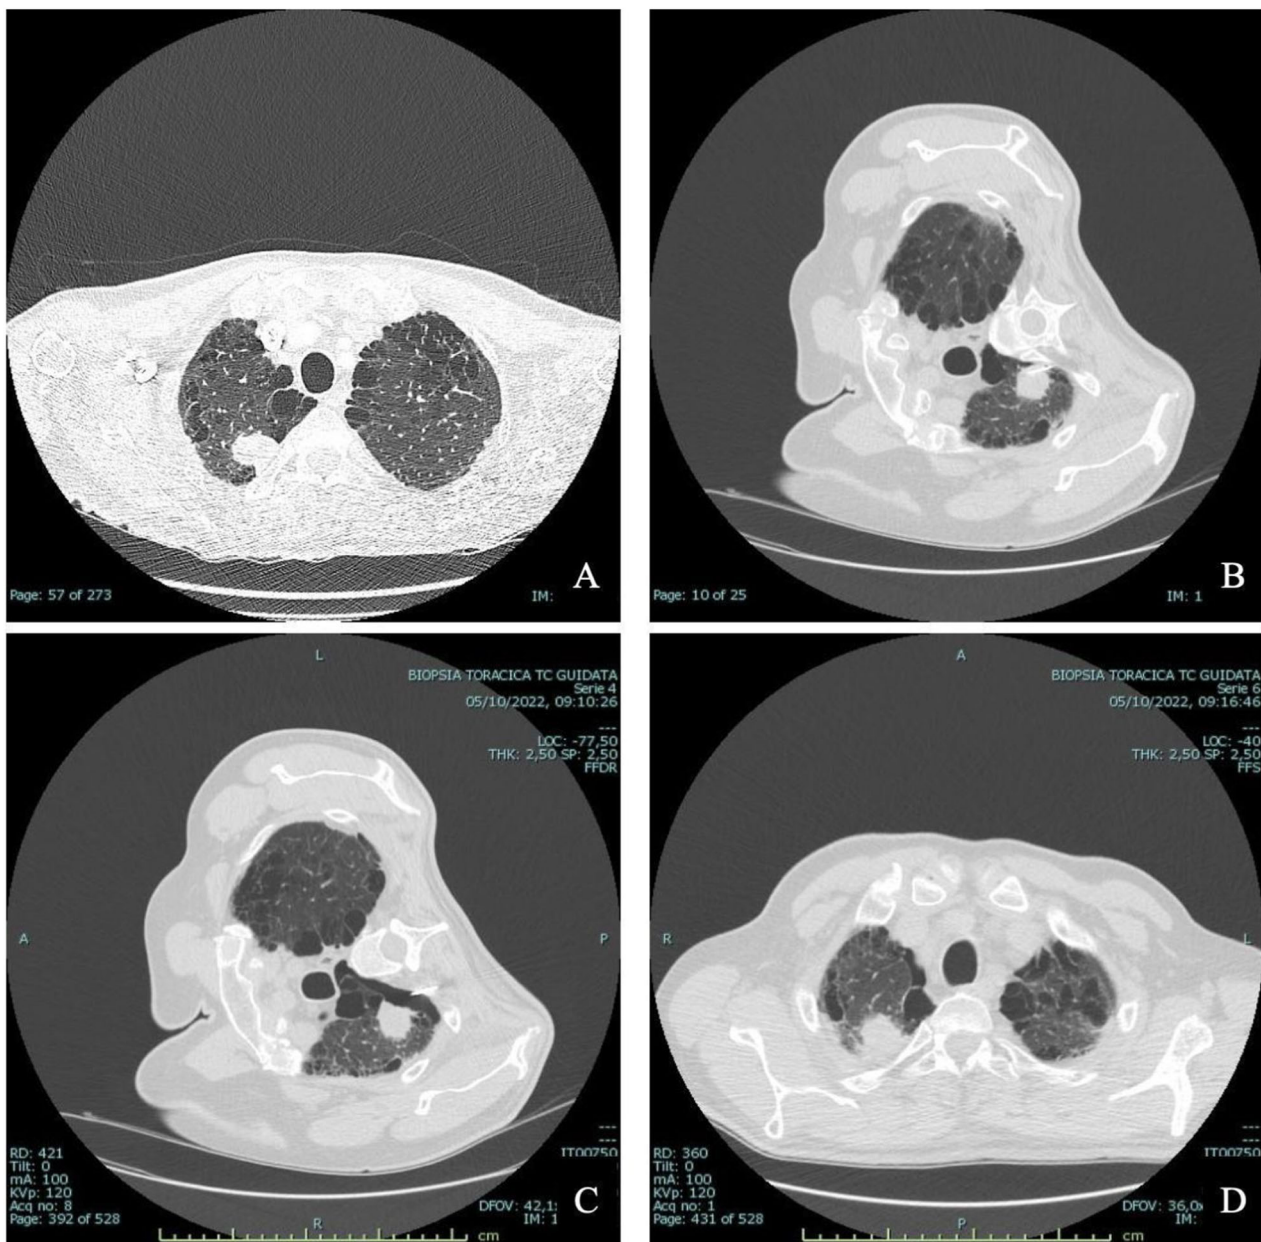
Biopsy in ipsilateral decubitus position. A Axial CT scan performed 5 days before the procedure shows a 30 mm solid lesion in the right upper lobe in a 70-year-old patient with severe emphysema. B Unenhanced axial CT scan displays the patient's right decubitus position with an 18 G biopsy needle inside the lesion. C Unenhanced axial CT scan shows the occurrence of posterior PNX. D Unenhanced axial CT scan obtained with the patient on puncture side-down position depicts PNX resolution, obtained applying pleural blood patch, needle removal during expiration, and rapid roll-over
